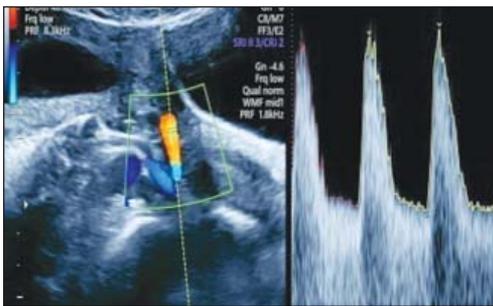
Uterine Artery Doppler
